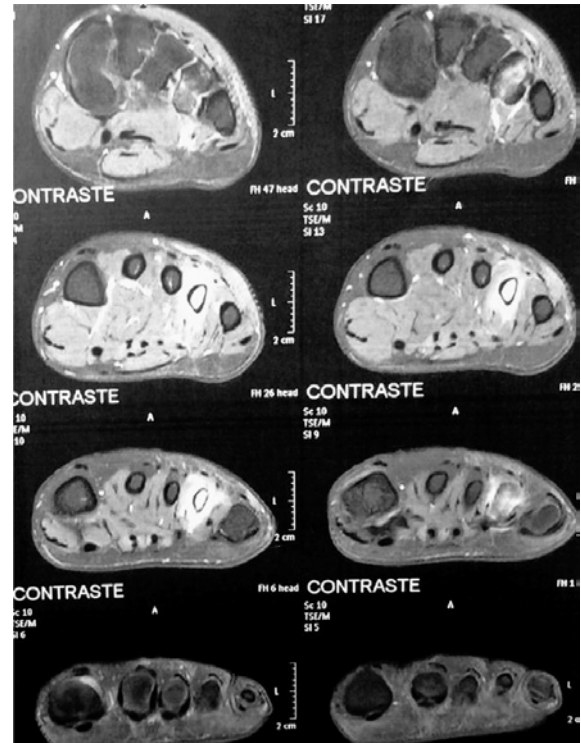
MRI: Coronal section with hypersignal in the fourth metatarsus.
